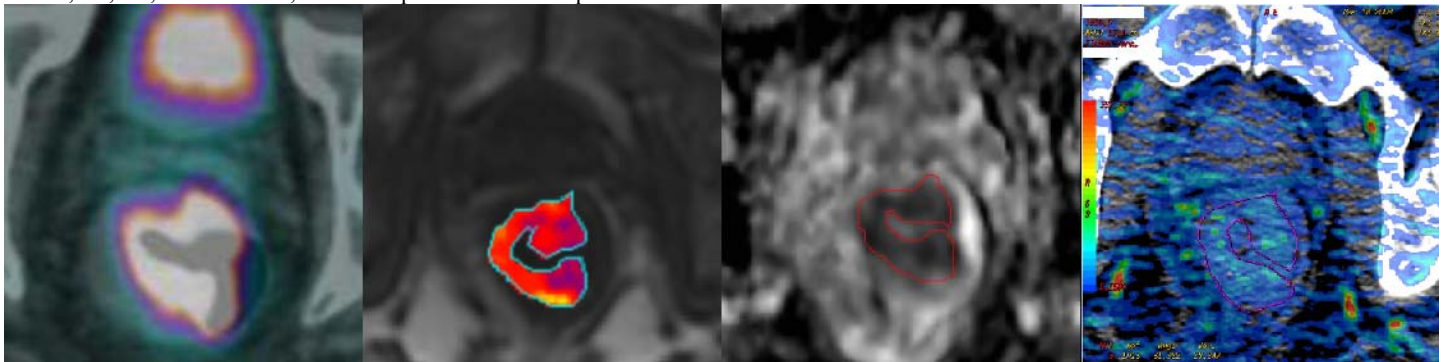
From left to right: PET SUV colourmap fused with CT, colour map of Ktrans, greyscale ADC map, CT BF colourmap of the same patient prior to undergoing neoadjuvant chemoradiation therapy.
